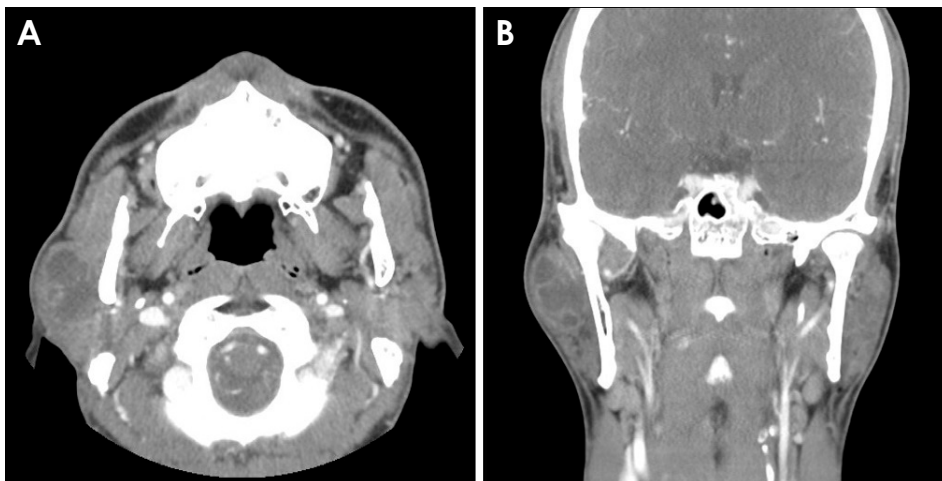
Axial (A) and coronal (B) contrast-enhanced computed tomography scans show an encapsulated and homogeneously enhanced multilocular soft tissue mass on the right parotid gland.
